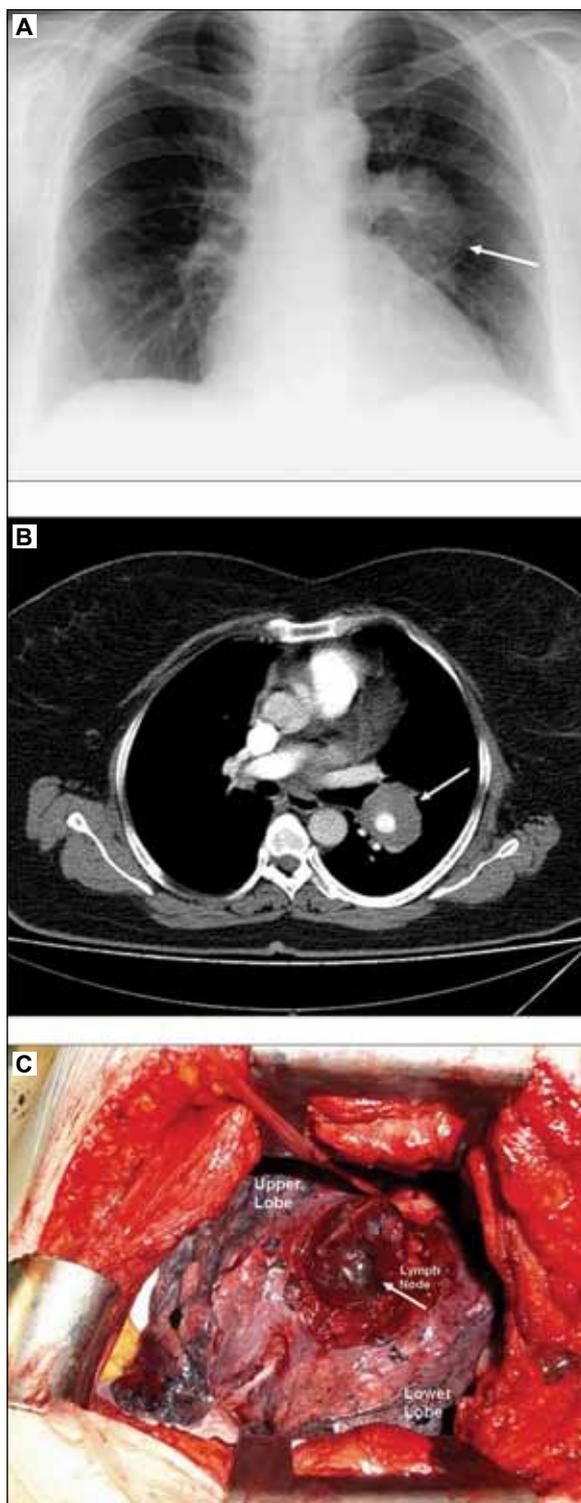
(a) Chest X-ray, (b) Intrathoracic mass around the left pulmonary artery on the computed tomography scan, and (c) Enlarged lymph node located in the left interlobar fissure.
